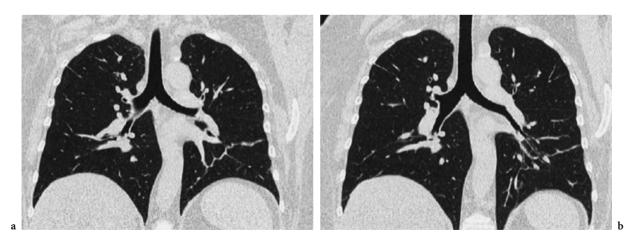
A 45-year-old woman 1.68 m tall and weighing 95 kg ($BMI = 35 \text{ kg/m}^2$) is referred for CT for follow-up of breast carcinoma and opacity in the left bases at chest radiography. Two CT acquisitions were performed, both using AEC. The first one (a) was obtained while the reference quality mAs was set at 90 mAs (effective). The second one (b) was obtained with a reference mAs reduced to 60 mAs (effective). Dose descriptors (CTDI_{vol} and DLP) are displayed. Compared to Fig. 6.4 obtained from a thin patient, the dose for a obtained in this obese patient was doubled automatically by the AEC device in order to maintain the image quality constant
